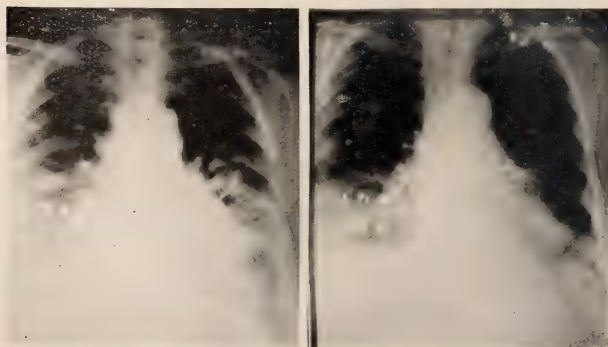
Case No. 14393—Mrs. E. C.—(1) Roentgenogram made when increase in density in the left lung was first recognized. (2) Same patient after the area of increased density had subsided, leaving only a small area of fibrosis.
